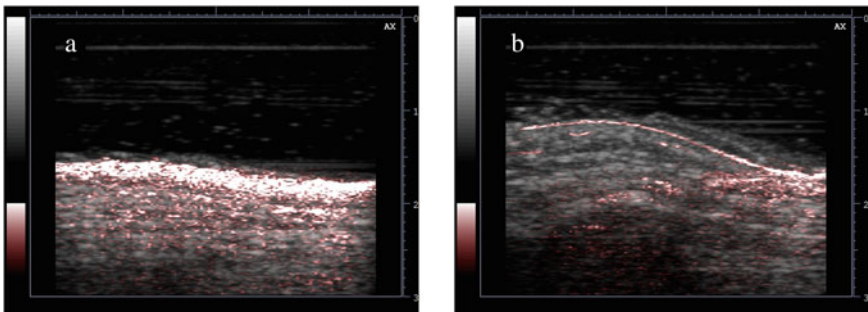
Typical photoacoustic/ultrasound overlay image of a PWS region (ROI) and b control region (HR)
